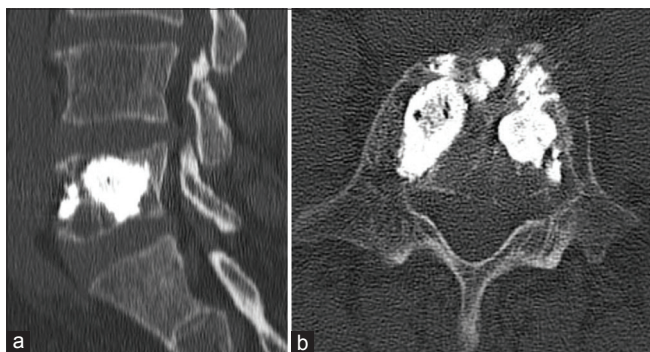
Postoperative mid-sagittal (a) and axial (b) computed tomography scans showing successful enhancement of the vertebral body and cement dispersion filling the vertebral body
